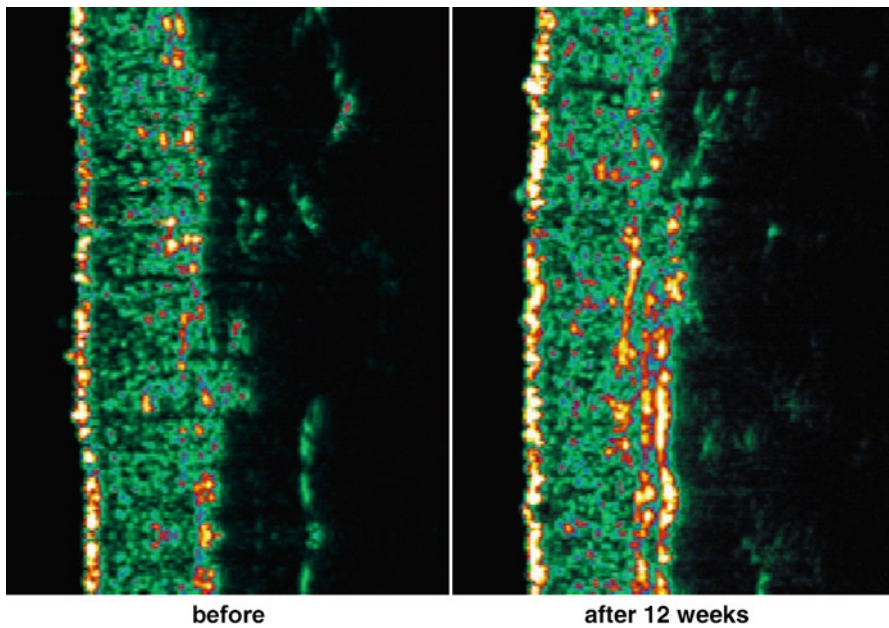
Skin density and thickness measurement with ultrasonography (B-Scan) before and after 12 weeks of supplementation with a dietary supplement containing mixed carotenoids (Heinrich et al. 2006b)
